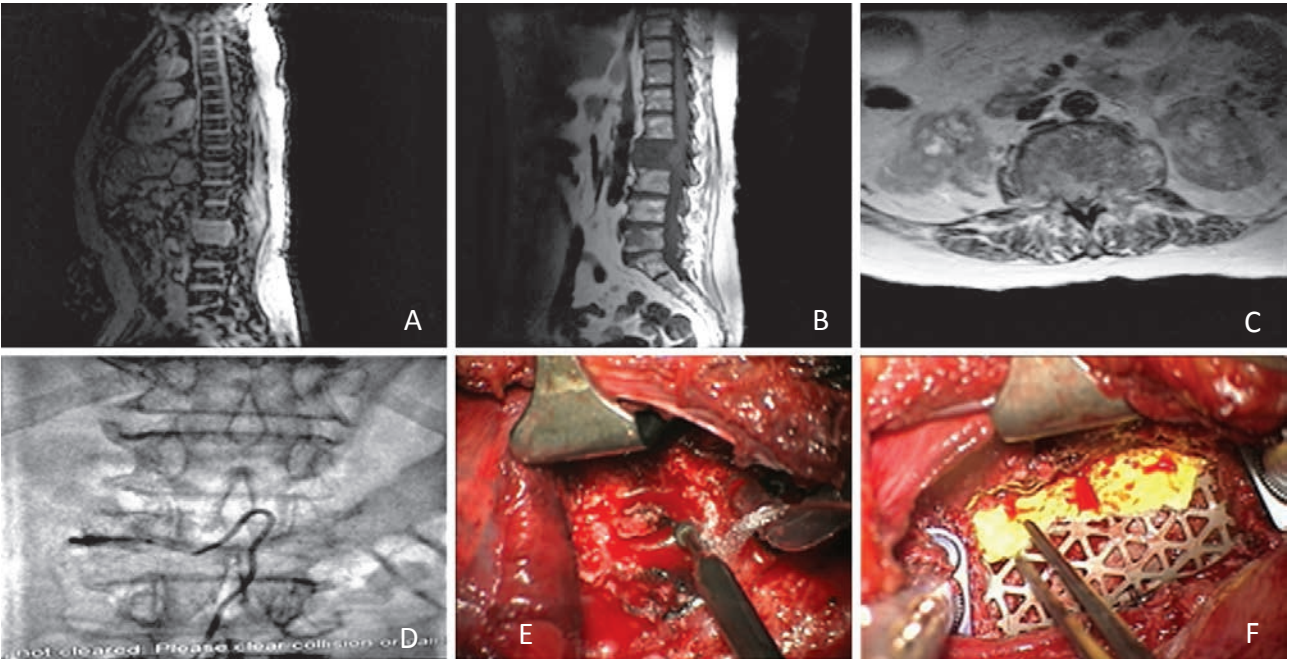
A,B,C: MRI showing LV2 mets. D: preoperative embolization. E,F: operative foto after corpectomy and cage insertion.
